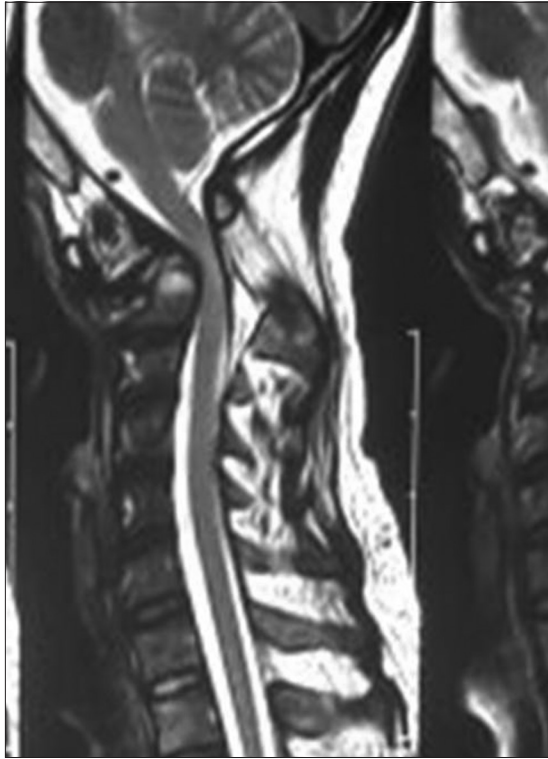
Cervical magnetic resonance imaging (sagittal view).
